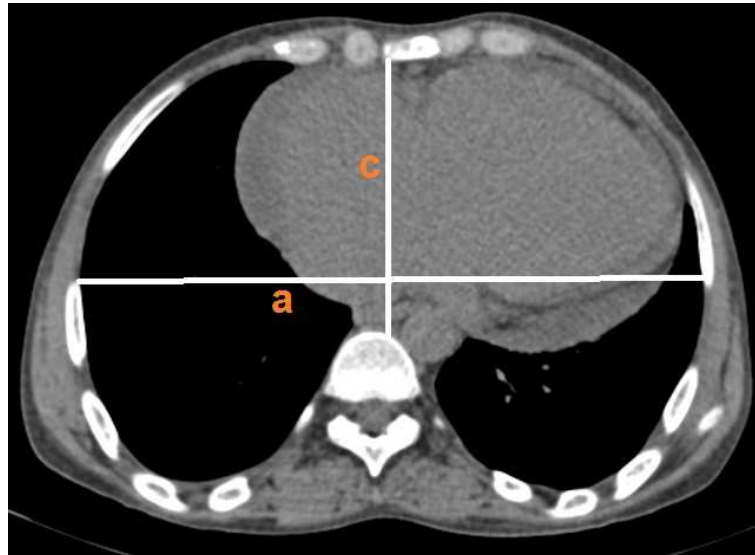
Non contrast CT image (transverse view) of thorax showing the measurement of haller's index
